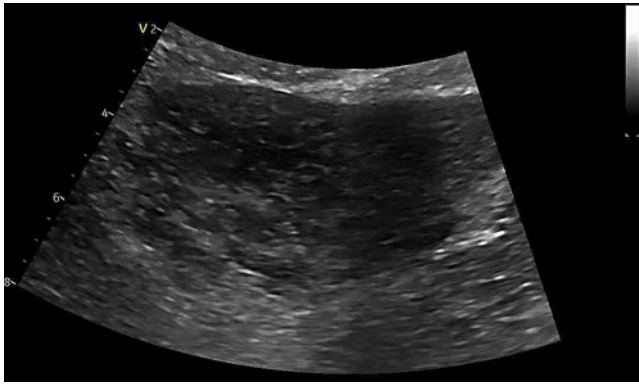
Abdominal ultrasound image showed the giant hypoechoic mass.
